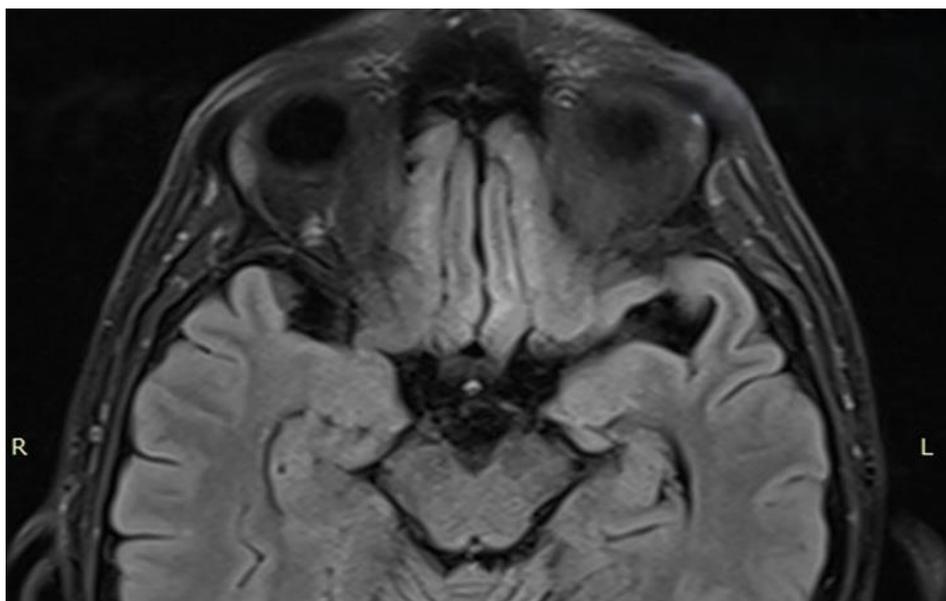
Magnetic resonance imaging fragment of Patient D., 65 years old
